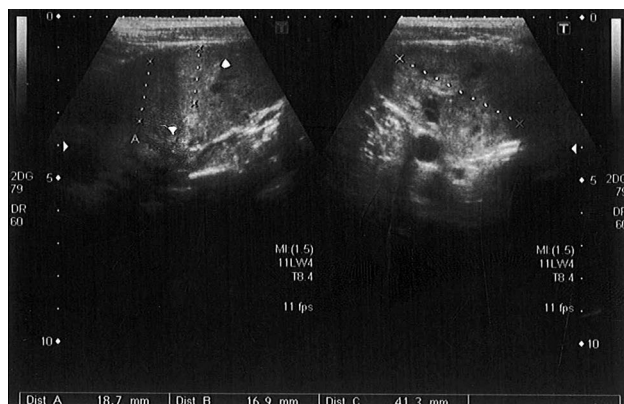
Neck ultrasonography: Diffuse multinodular goiter.
